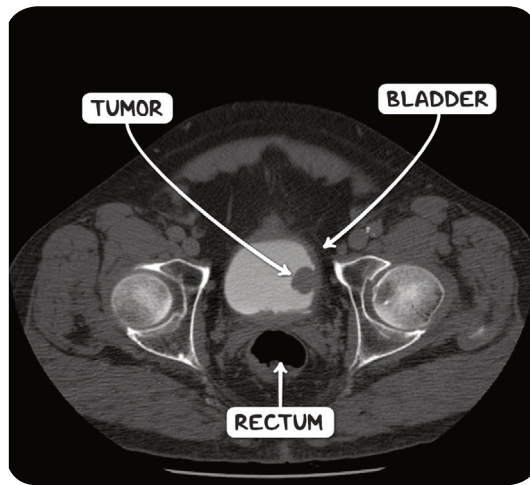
An MRI scan in the axial plane demonstrating a transitional cell carcinoma of the bladder.
